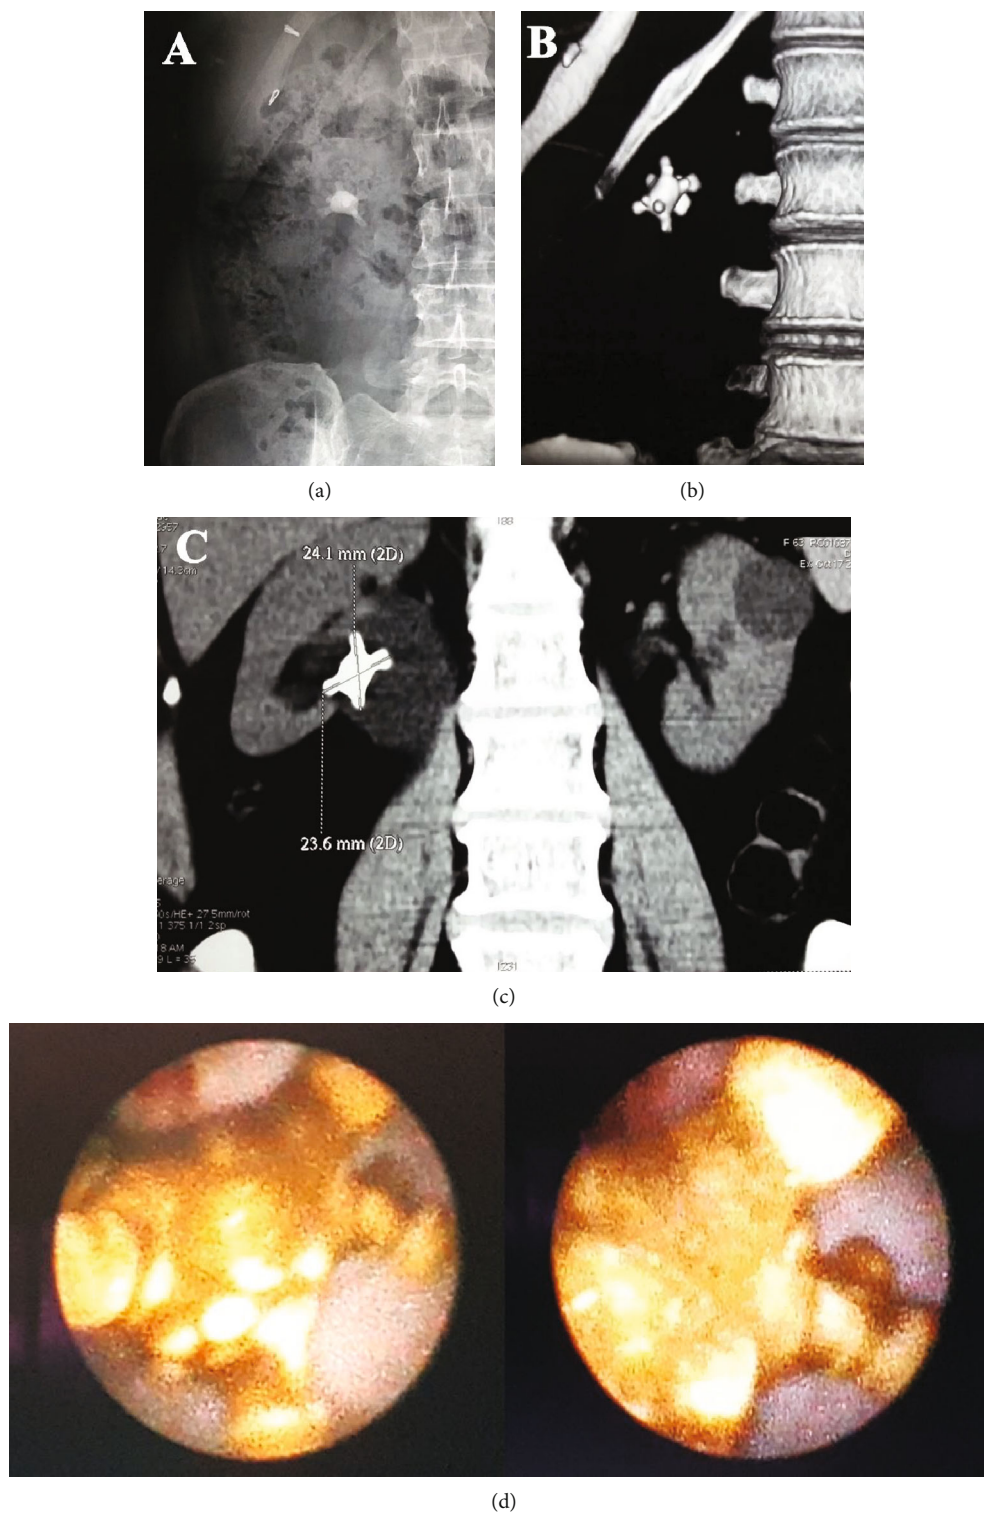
(a) X-ray: typical jackstone in the right kidney. (b) Reconstructed image of noncontrast computerized tomography (NCCT) confirming the presence of jackstone. (c) NCCT showing the right renal jackstone with mild hydronephrosis and no proximal hydroureter. (d) Endoscopic images showing a jackstone.
